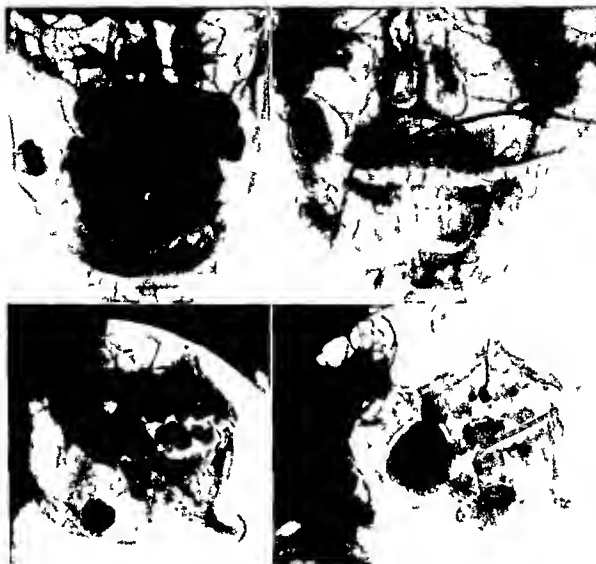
Roentgenogram of an extensive ameloblastoma of the right mandible in a patient 19 years old (*Top left*) Inclusion of molar in the cystic neoplasm (*Bottom left*) Lateral roentgenogram of ameloblastoma of right mandible (*Top right*) Following injection of ameloblastoma with iodized oil Catheter can still be seen in position in cavity of ameloblastoma inserted through opening remaining after removal of incisor tooth Difference in shadows between iodized oil and outer wall of ameloblastoma denotes actual thickness of lining of the cavity Constriction in iodized oil shadow denotes almost complete separation of ameloblastoma into two locules (*Bottom, right*) Lateral roentgenogram Note constriction in shadow At operation only a very narrow communication was found between the two extremities of the ameloblastoma (Fig 371B)
